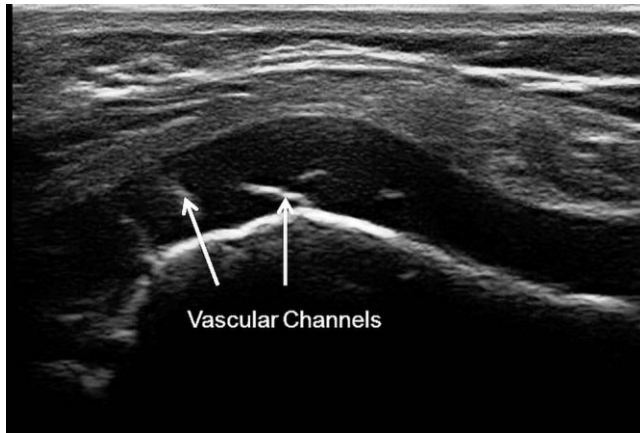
Ultrasonographic image of the medial femoral condyle. This ultrasonographic image of the femur condyle in a 3-year-old child shows hyperechoic spots within the cartilage that correspond to vascular channels.
